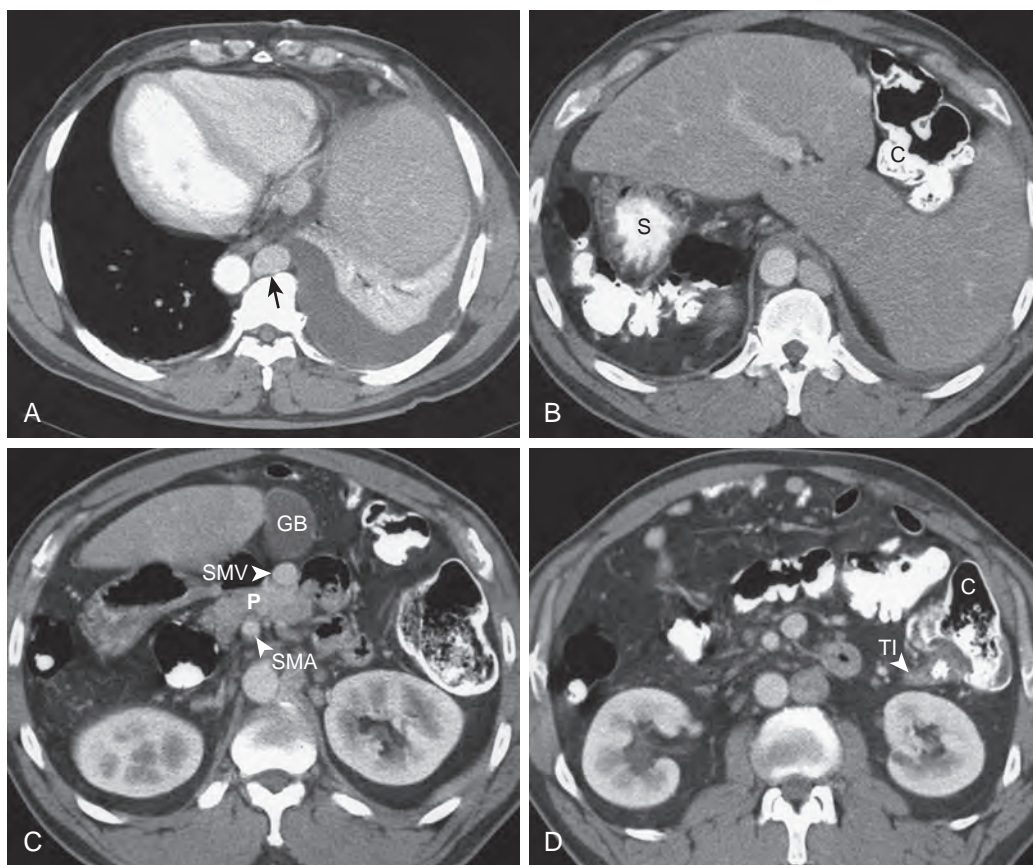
Situs ambiguus with asplenia. A. Transverse contrast-enhanced CT scan of the lower chest of a 48-year-old man shows dextrocardia and azygos continuation of the inferior vena cava. The aorta is located to the right of the enlarged azygos vein (arrow). The scan also shows left lower lobe collapse and a left pleural effusion. B. CT scan obtained 15 mm caudad to A shows the stomach (S) and colon (C) in the expected location of the spleen. The hypoplasia of the anterior segment of the right hepatic lobe allows cephalic migration of the colon. C. On another CT scan obtained caudad to B, the gallbladder (GB) lies in the midline. The superior mesenteric vein (SMV) lies anterior to the truncated pancreas (P), whereas the superior mesenteric artery (SMA) lies posterior to it. D. CT scan obtained at the level of the right renal hilum reveals that the cecum (C) is located in the left lower quadrant. Notice the terminal ileum (TI) entering the colon. (From Fulcher AS, Turner MA: *Abdominal manifestations of situs anomalies in adults*. *RadioGraphics* 22:1439–1456, 2002.)
